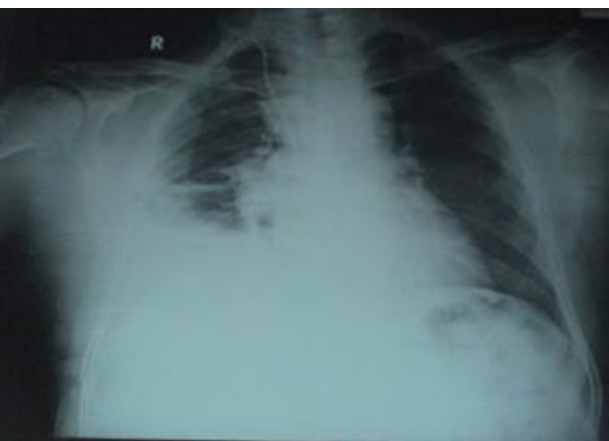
Chest X-ray taken on the 2nd postoperative day.
